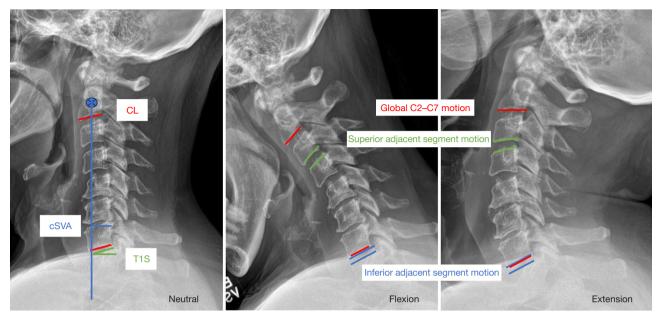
Example of measurements made on lateral X-rays, including CL, cSVA, T1S, and Cobb angles to measure global (C2–C7) lordosis, and adjacent segment lordosis (superior and inferior). CL, cervical lordosis; cSVA, cervical sagittal vertical axis; T1S, T1 slope.
